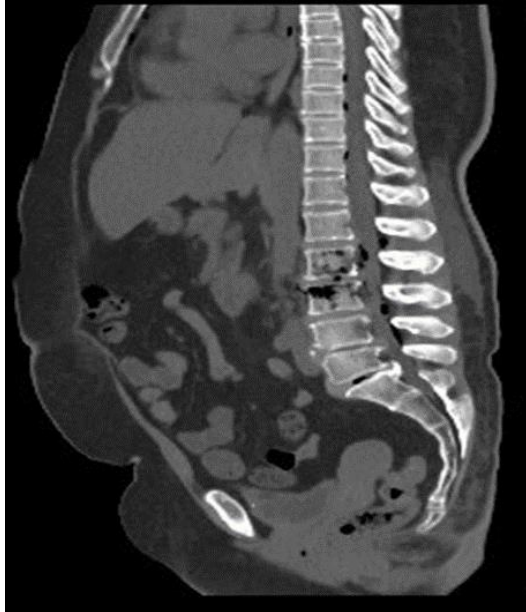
CT abdomen sagittal view showing intraosseous air in L2 and L3 vertebral bodies extending into intra-vertebral and epidural space.
